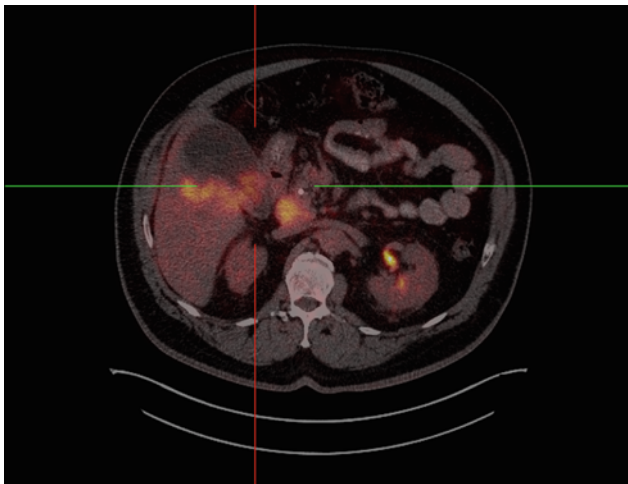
54 year-old male with a newly found gallbladder mass. Axial fused staging 18F-FDG PET/CT image demonstrates intensely FDG-avid gallbladder wall thickening involving the posterior wall (SUV-max 10.1) and the hepatic parenchyma
